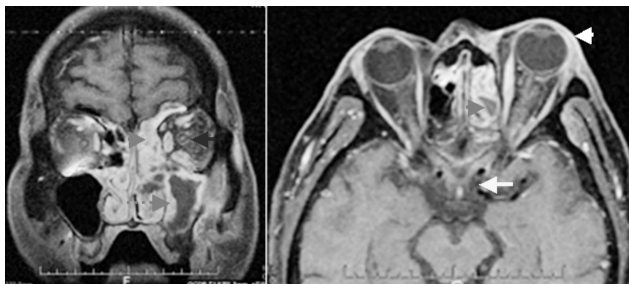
MRI prominent left ethmoidal sinus (solid red arrow) and maxillary sinus (dotted red arrow), left optic perineuritis (blue arrow) with left proptosis (white arrow) and normal cavernous sinus (yellow arrow)
